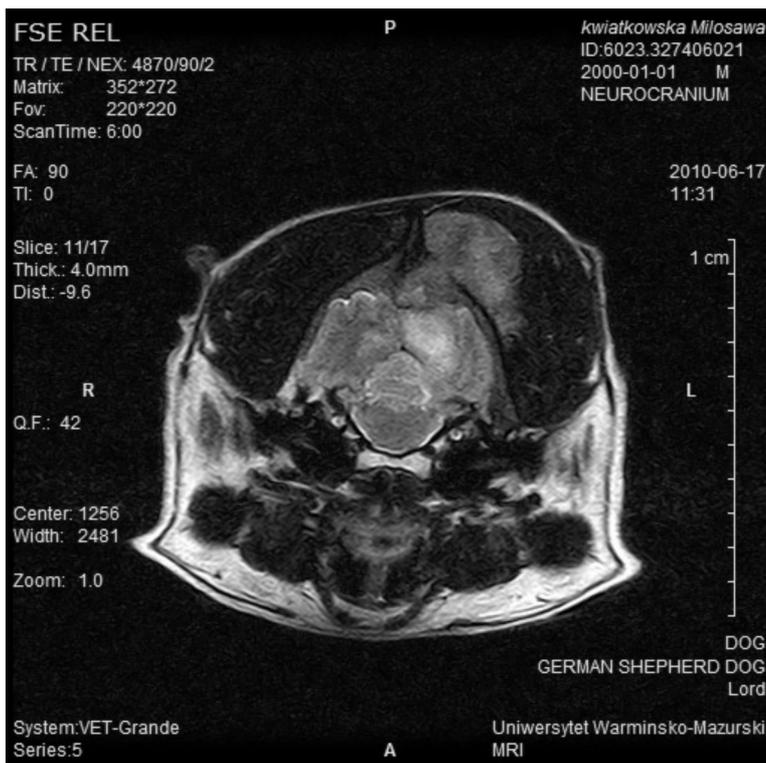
MRI revealed heterogeneous masses covering the left occipital and parietal lobes isointense to hypointense to the brain on T2-weighted FSE sequences in the transverse plane.
